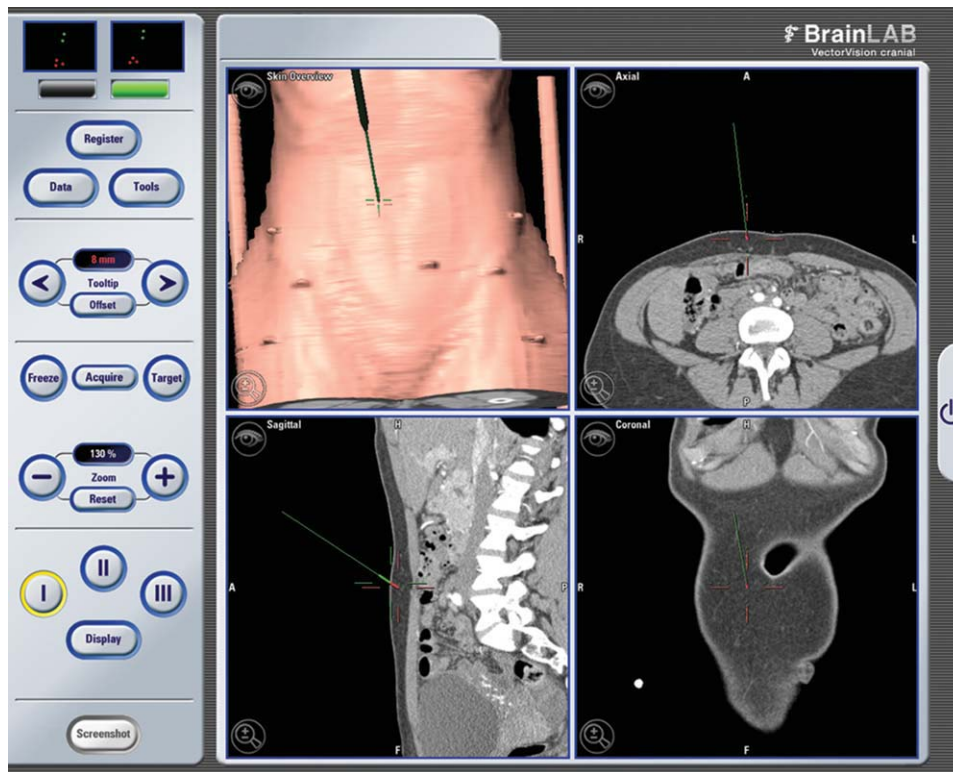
Stereotactic image-guided navigation of a computed tomography angiogram (CTA) of the abdominal wall vasculature, with three-dimensional reconstructed images shown on BrainLAB Vector Vision Cranial<sup>®</sup> software, demonstrating coronal, sagittal and axial planes of a localized deep inferior epigastric artery (DIEA) perforator. [Color figure can be viewed in the online issue, which is available at [wileyonlinelibrary.com](http://wileyonlinelibrary.com).]
